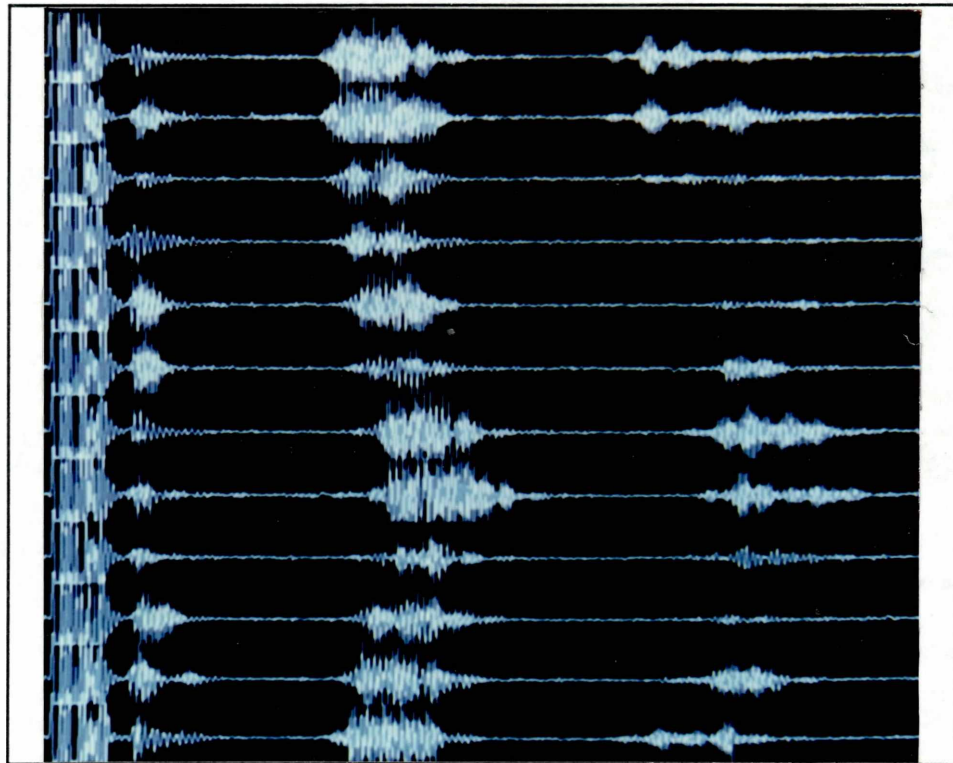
The ultrasounic signals captured by the 4 mm Ring Array Transducer.
